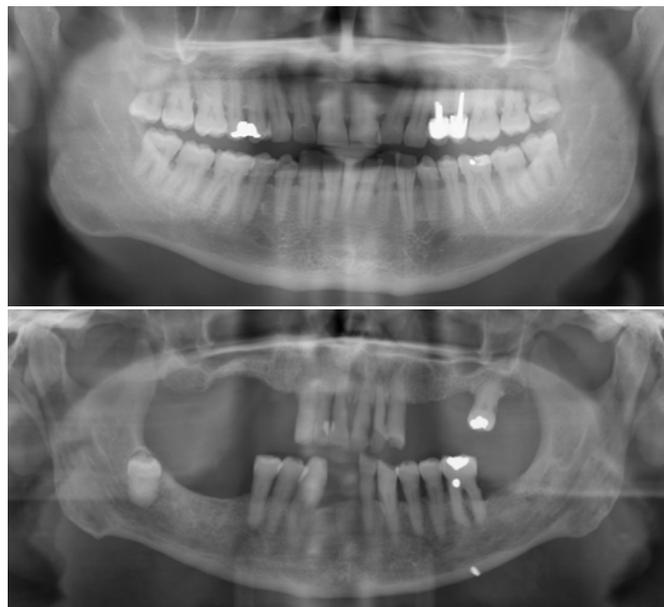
Panoramic x-ray of a patient with severe, proliferative diabetic retinopathy without clinical attachment loss shown on the top vs. an OPG of a patient with mild, non-proliferative diabetic retinopathy showing advanced clinical attachment loss shown above.
